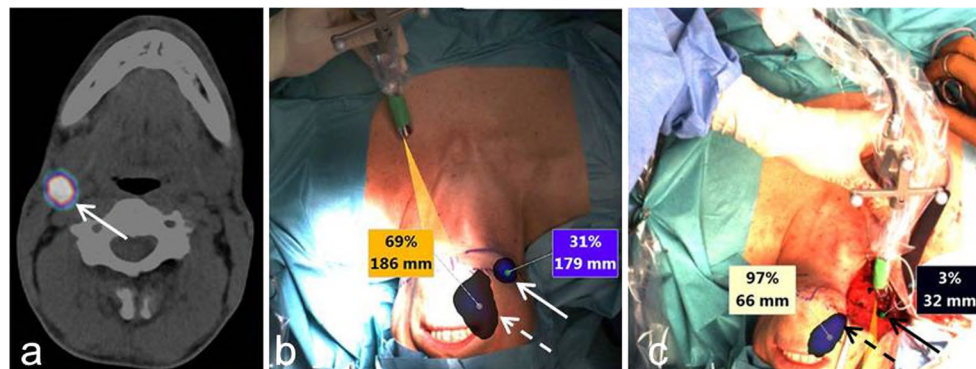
Additional radioactive node. a Preoperative scintigraphy (SPECT/CT) image shows a SLN dorsal to the glandula submandibularis on the right side. b Preincision scan with the injection site (dashed arrow) and a SLN in level II (arrow). The boxes show the percentage distribution
